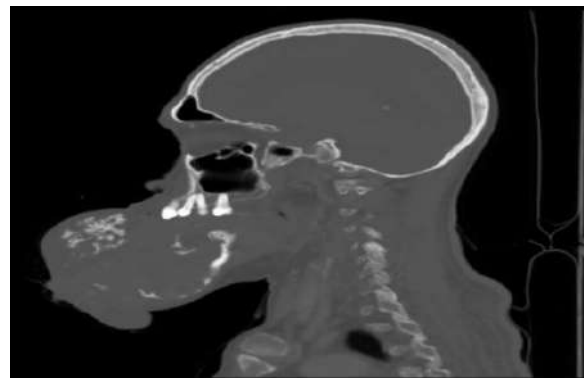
Lateral CT Scan examination
